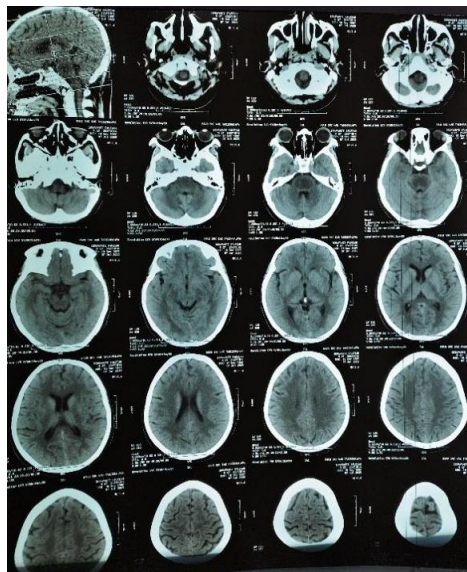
Head CT Scan without contrast showing a hypodense lesion in the brainstem (blue arrow).
